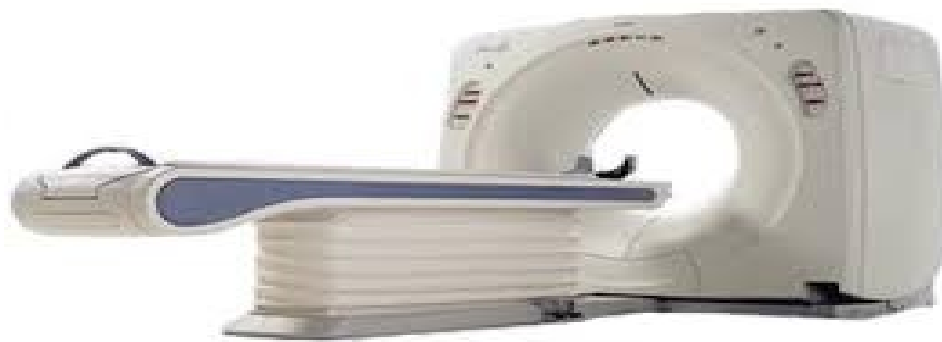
CT scanner (Nunes,2010)
